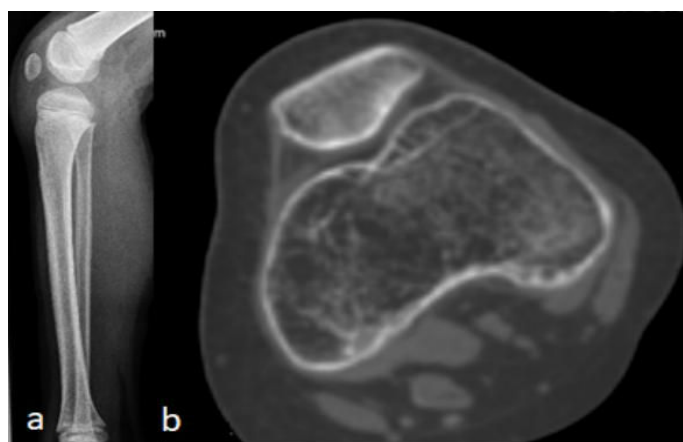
Lateral knee radiograph in a 14-years-old boy showed small and dysplastic rounded patella (a). 3D axial CT scan of a-10-years-old-boy (different patient) showed a fragmented and irregular trochlear dysplasia (b).
